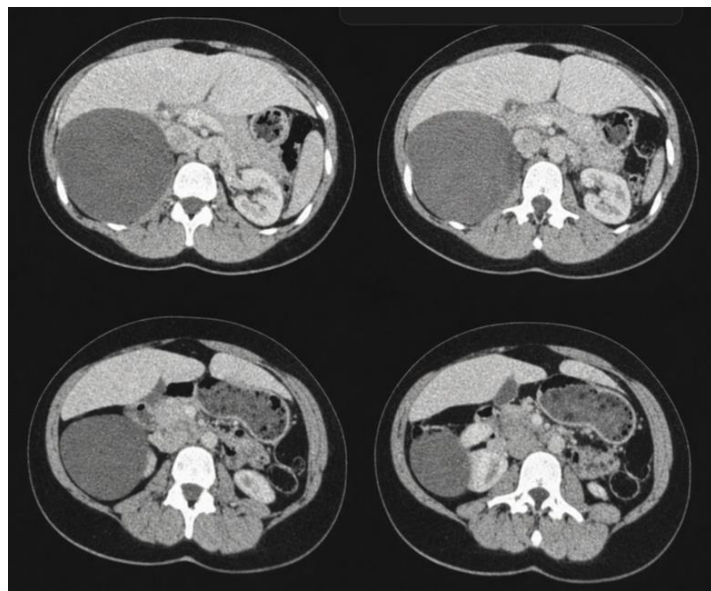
Axial CT scan of the TAP c+, showing a cystic mass located between the liver and the kidney, with thin walls and fluid-filled contents, measuring 115 x 117 x 158 mm with no calcifications or internal septa. (Department of Visceral Surgery 'I', HMIMV, Rabat, MOROCCO)
